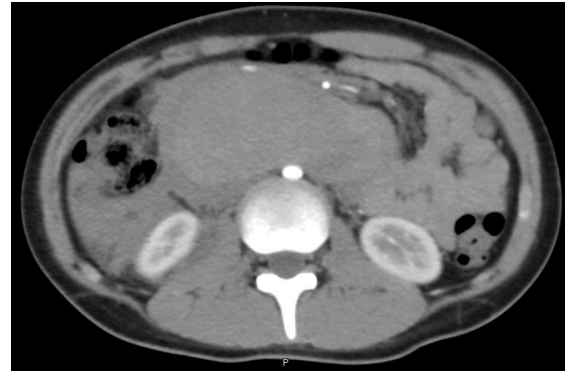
Non-contrast and arterial-phase abdominal CT. Hematoma of the duodenal wall of the third and fourth portions with associated retroperitoneal blood.
